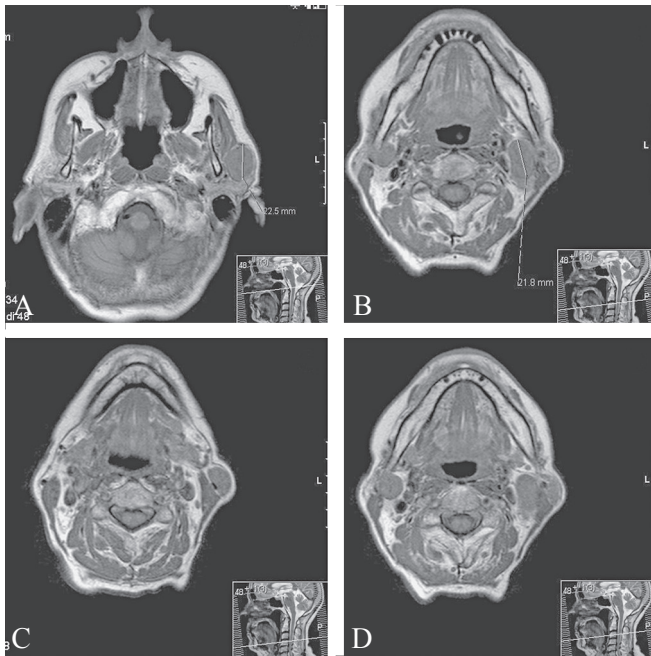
Imaging findings. Axial T1-weighted magnetic resonance imaging. A) 2.2 cm right nodule in the superficial lobe; B) 2.1 cm right nodule in the deep lobe; C) 1.0 cm right nodule in the superficial lobe, which was actually an extra-parotid localization; D) 2.0 cm left nodule in the superficial lobe.
